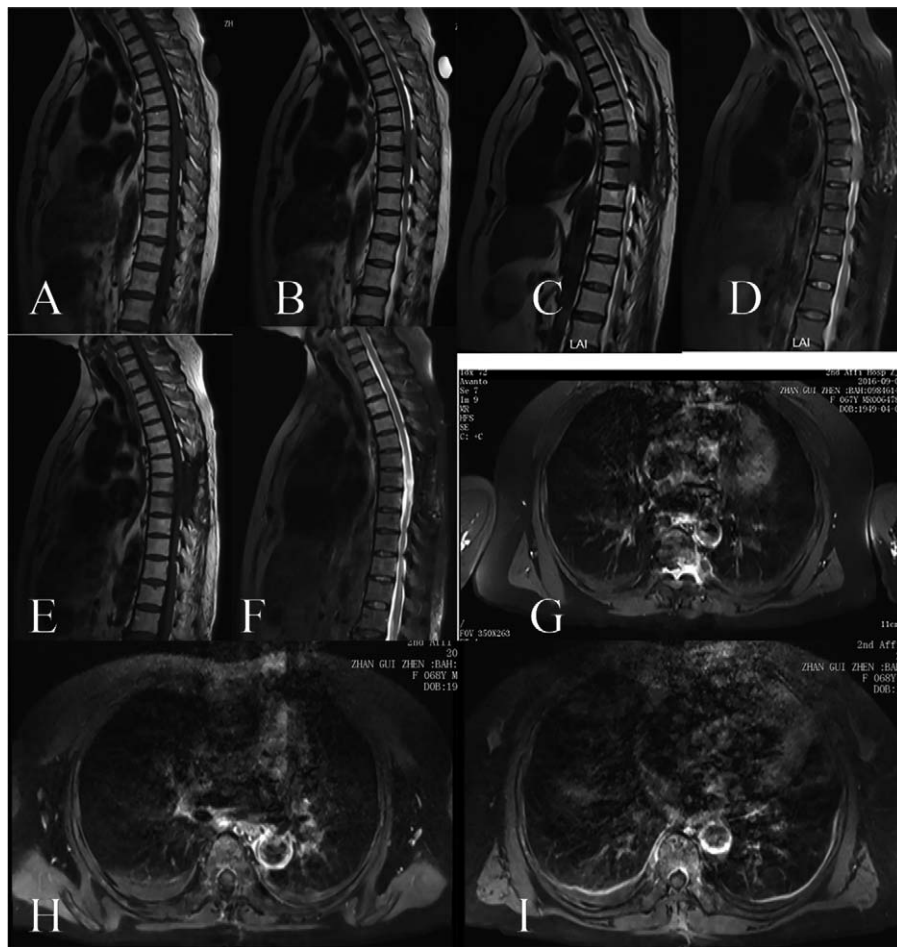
Magnetic resonance images at the initial visit (A, B, G), postoperation and after 1 cycle of chemotherapy (C, D), and at the latest follow-up (May 29, 2017) (E, F, H, I). (A, B) Sagittal plane at T6–7 showing abnormal lesion located in the epidural space of the thoracic spinal canal. (G) Axial planes note the mass extending through the foramen forming a paravertebral tumor (arrows). (C, D) Sagittal plane demonstrates the tumor at the thoracic spine, which had been partially resected and chemotherapy showed complete disappearance. (E, F, H, I) There was no recurrent tumor in the epidural space at the last follow-up.
